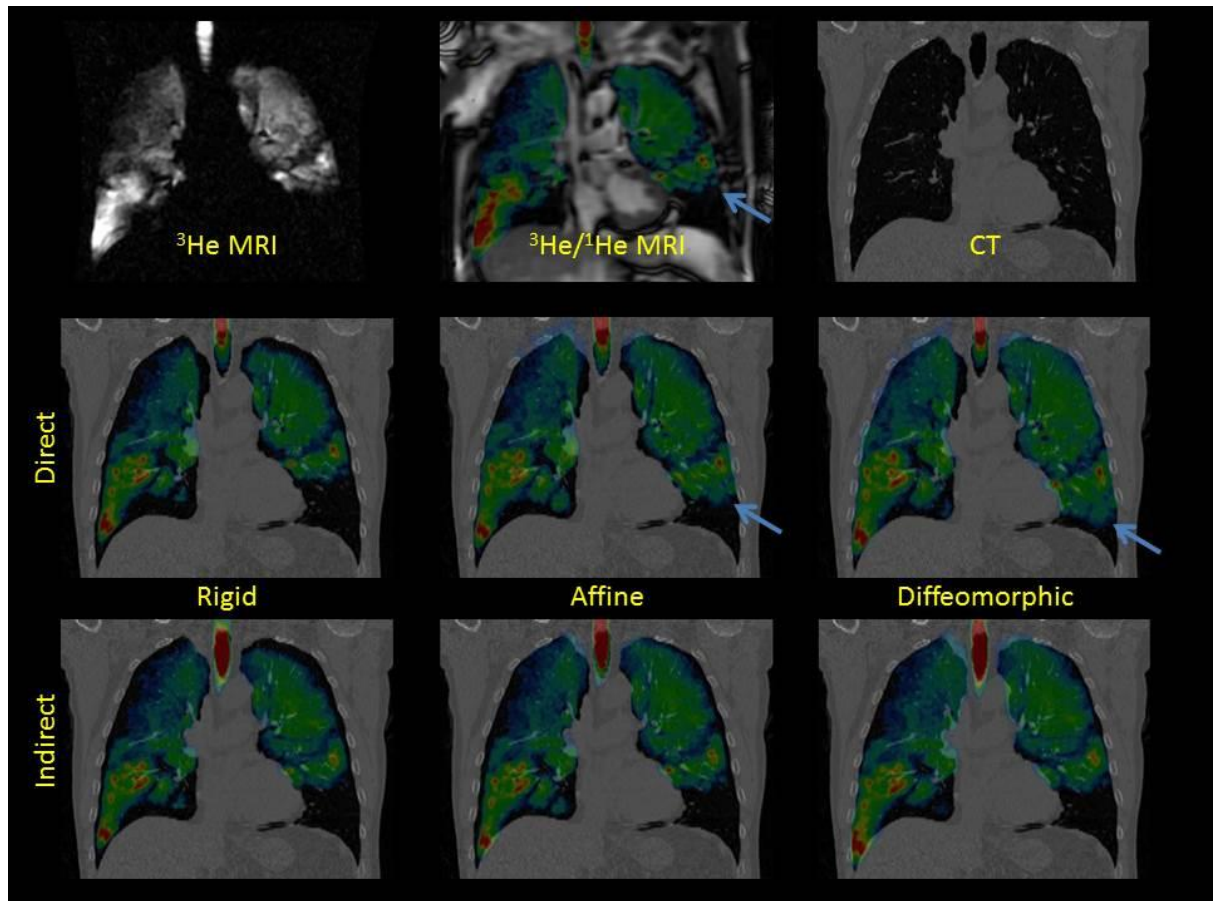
Corresponding coronal slices of patient 14 showing registered ^3He MRI fused with CT via the direct (middle row) and indirect (bottom row) rigid, affine and diffeomorphic methods with preregistered ^3He MRI (top left), ^1H MRI fused with ^3He MRI (top centre) and CT (top right). The blue arrows near the base of the left lung indicates a registration error in the direct affine and diffeomorphic methods when compared to the corresponding slice of the unregistered ^3He MRI.
